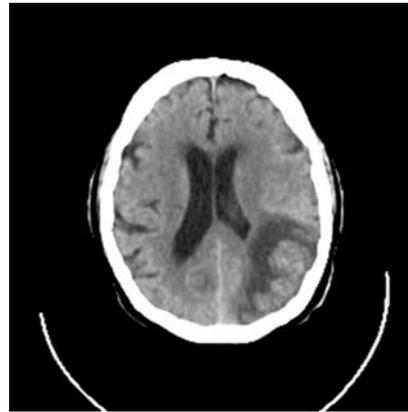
Computed tomography of the brain one week after the patient's admission, indicating a lesion on the left parietal lobe
